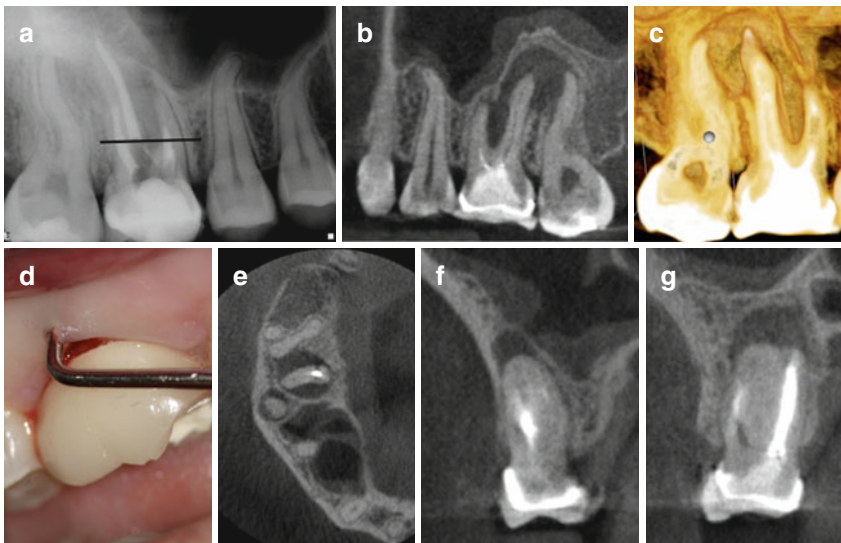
Periapical radiograph of tooth #3 that was referred for periapical surgery (a). A nonsurgical retreatment attempt was performed prior to periapical microsurgery. The mesiobuccal canal was blocked. The *black line* in (a) corresponds to the level of the axial view in (e). Sagittal view demonstrating the extent of the periapical defect (b). 3D rendering of the periapical defect (c). Clinical picture demonstrating the endodontic/periodontal communication (d). Axial view of the mesiobuccal, distobuccal, and palatal roots (e). Note the fused distal and palatal roots. Coronal view of the mesiobuccal root and the fused distal-palatal roots (f, g)
